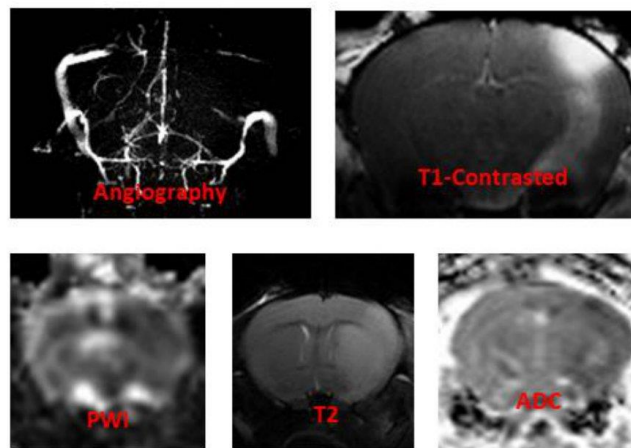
The sequences obtained by MRI. Comprehensive MRI protocol was applied using MR angiography, T1-contrasted, perfusion-weighted imaging (PWI), T2, and Apparent diffusion coefficient (ADC).
